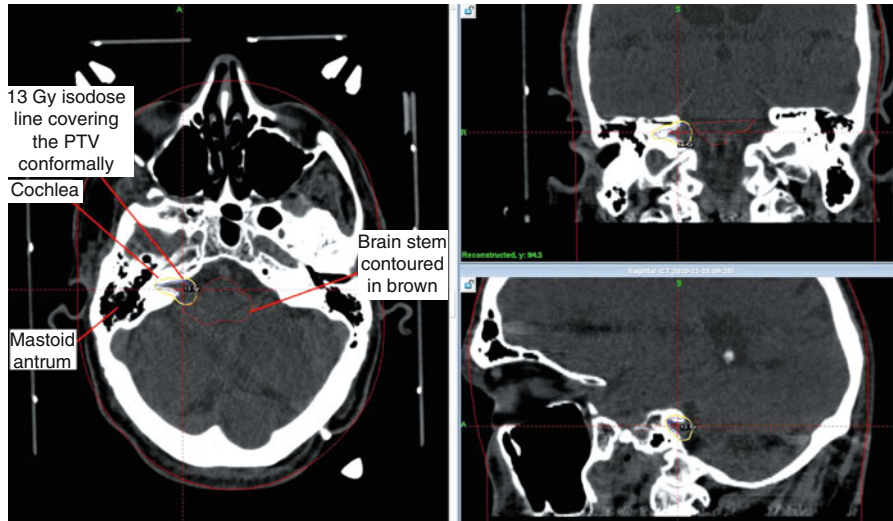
Vestibular schwannoma treated with SRS (axial, coronal, and sagittal CT bone window views)
